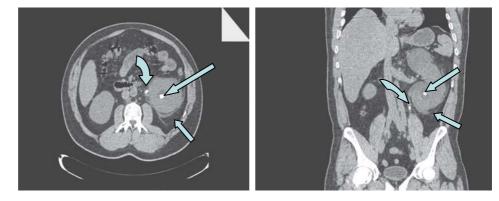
Unenhanced axial CT scan (left) and coronal (right) reconstruction CT images shows left renal enlargement, dilatation of left pyelocaliceal system and stranding of perirenal fat (short arrow) due to left proximal ureteric (curved arrow) and left renal calculi (long arrow).
